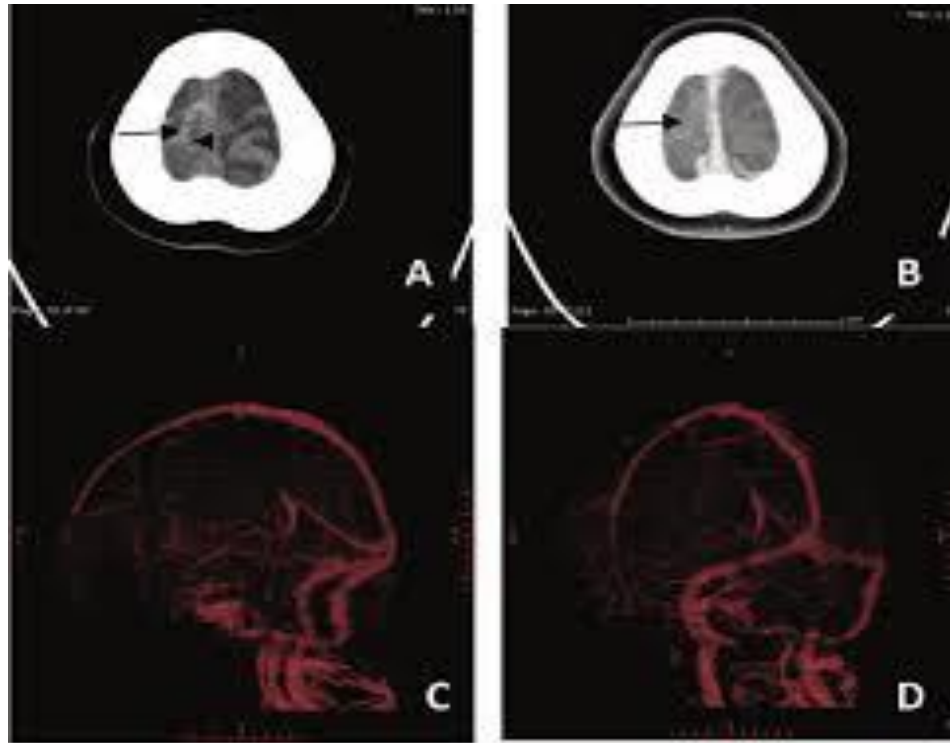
Axial computed-tomography scan demonstrates A,B) intraluminal hyperdensity of clot at right sided of superior sagittal sinus wall, cortical veins of right frontal regions (cord sign, arrow). CT venography showed (C,D) no contrast filled in thrombosed cortical vein in right frontal region. The dural venous sinus is well opacified by contrast medium.
